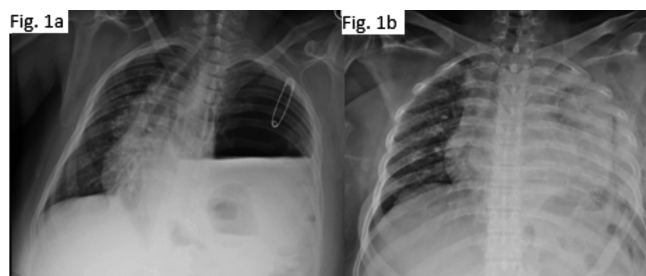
a) Chest roentgenogram showing left side hydropneumothorax with mediastinal shift to the right; b) post-tube thoracostomy chest roentgenogram.
